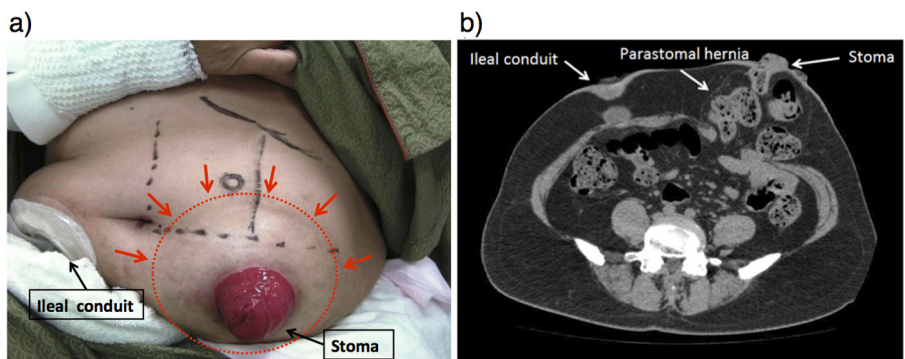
a) The patient had a large parastomal hernia in the left lower abdomen and an ileal conduit in the right lower abdomen. b) Abdominal CT scans showed a large parastomal hernia of a stoma with herniation of transverse colon.
